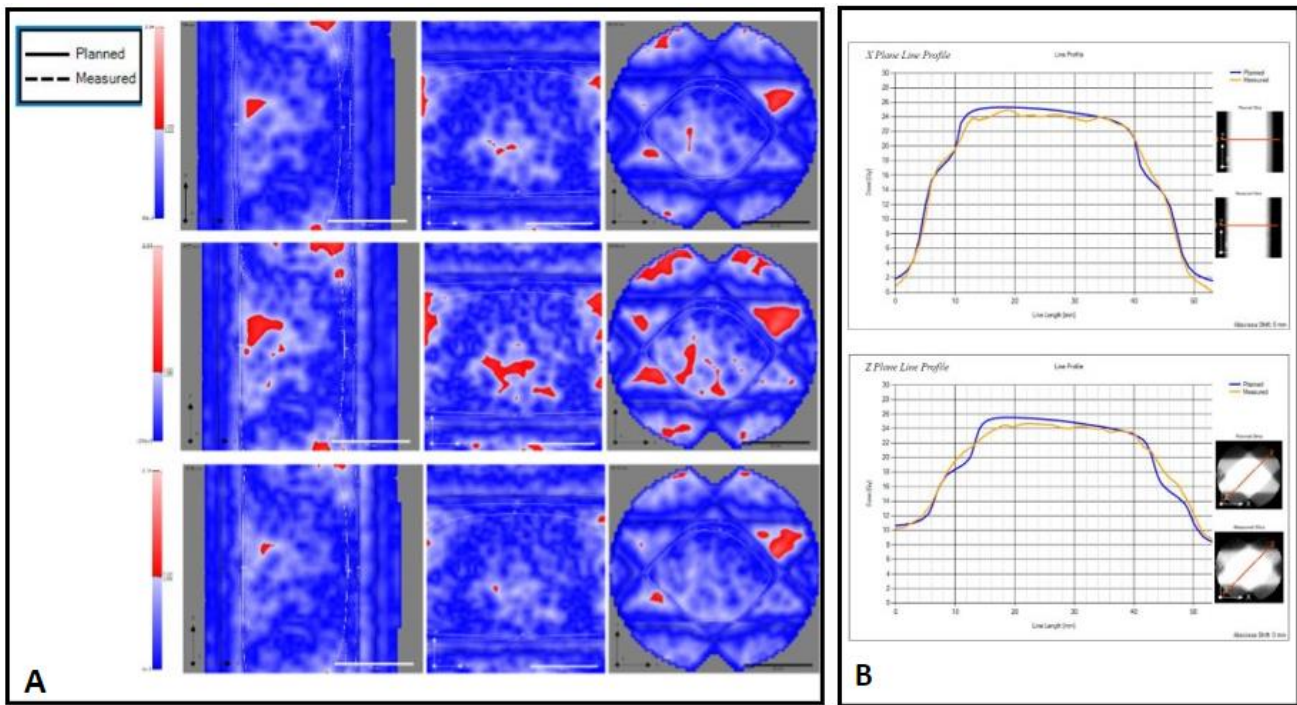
A: Gamma maps (iterative_CBCT data) for 3%/3mm (Top), 3%/2mm (Middle) and 5%/2mm (Bottom). B: Line Profiles across X plane (Top), and Z plane Bottom).
